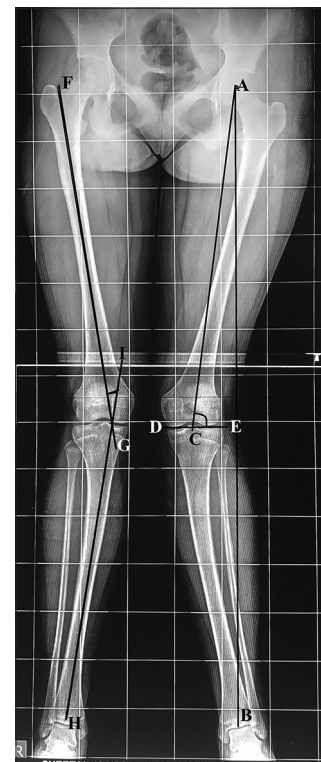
Antero-posterior radiograph of bilateral hip, knee and ankle showing different angle measurements. Line AB = Mechanical axis of the lower limb; AC = Mechanical axis of femur; DE = Articular surface of distal femur; FG = Anatomical axis of femur; HI = Anatomical axis of tibia. Tibiofemoral angle = Angle between line FG and line HI; lateral distal femoral angle = Angle between line AC and DE
